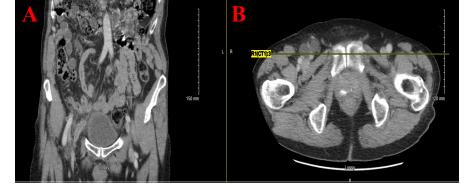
(A) Coronal CT image showing appendix (red arrows) within a right inguinal hernia. (B) Axial pelvis CT image showing the looped herniated appendix in the right inguinal canal.
